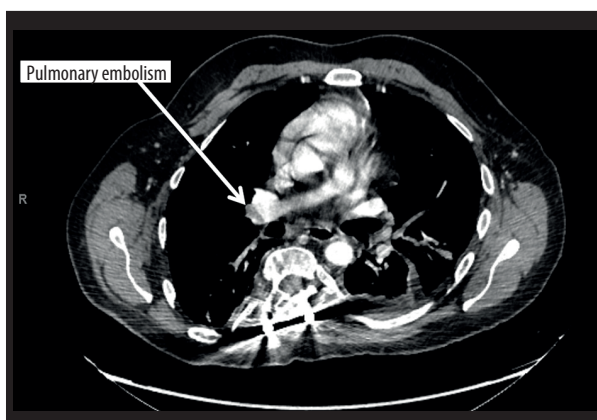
Computed tomography scan with middle right lobar pulmonary embolism.
